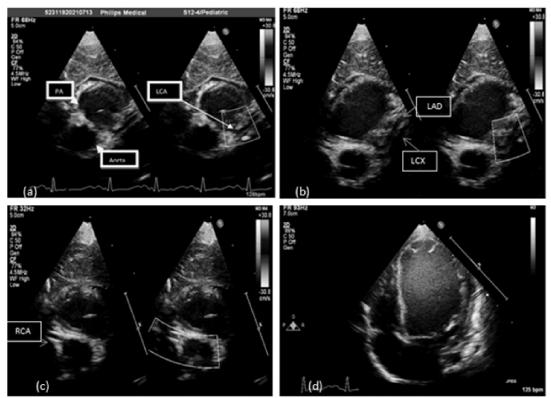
(a) Parasternal short axis view (PSAX) showing LCA originating from posterior facing sinus of PA.
